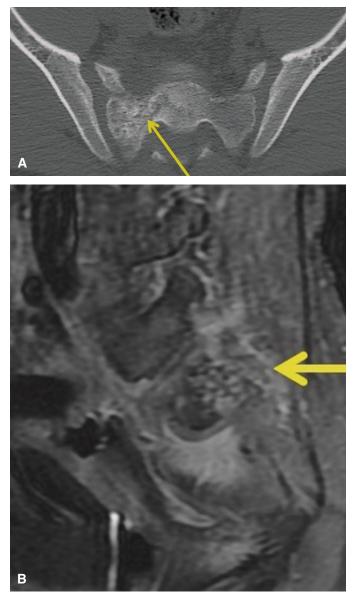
Vertebral Ewing sarcoma. *A*: Axial, CT scan with bone window shows a mixed lytic and sclerotic lesion predominantly involving the right side of S2 vertebral body (*yellow arrow*). No new bone formation is present. *B*: Sagittal, contrast-enhanced, fat-saturated MR image shows heterogeneously enhancing lesion centered within the right side of S2 vertebral body (*yellow arrow*). (Images courtesy of Vinay Kandula, MD, Nemours Alfred I. duPont Hospital for Children, Wilmington, Delaware.)
